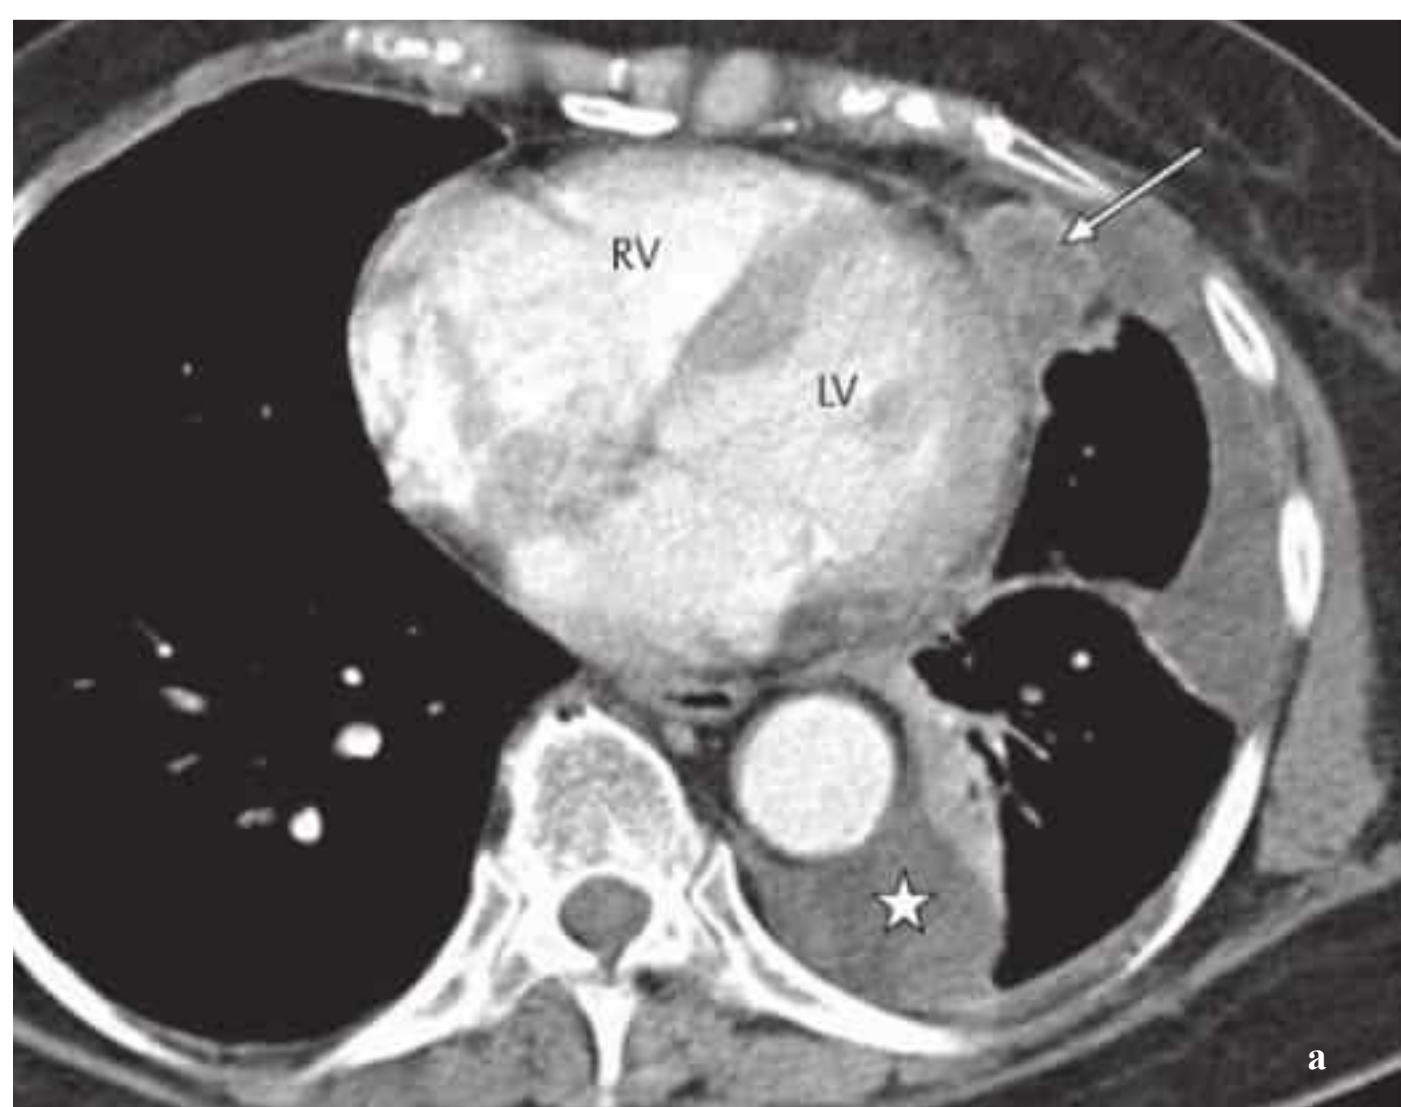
a, b Contrast-enhanced CT of a pericardial metastasis (arrow) anterolateral to the left ventricle shows mainly peripheral enhancement in the early phase (a) and soft-tissue attenuation in the late phase (b). CT also shows a loculated posterior pleural effusion on the left side (star) and hypoventilated areas in the adjacent lung.
